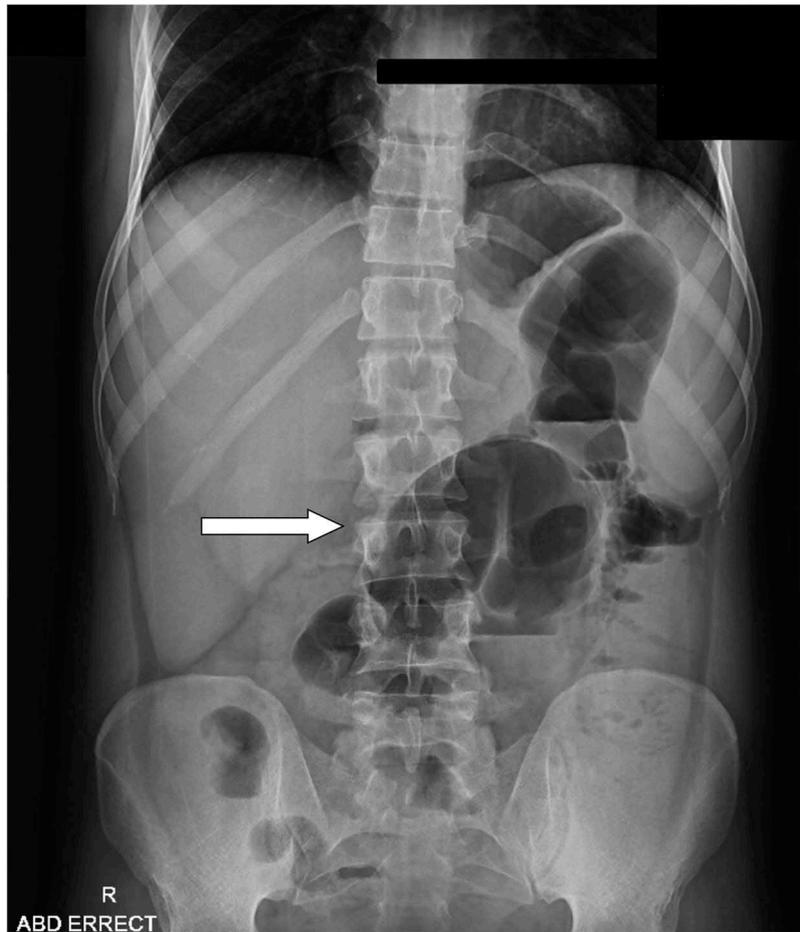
X-Ray Abdomen (erect) depicting the Coffee Bean sign of sigmoid volvulus.
